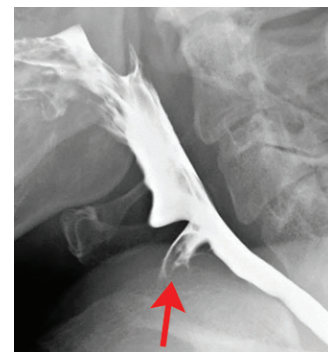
Frozen pharynx in a 68-year-old woman with a history of radiation therapy. Lateral radiograph shows absent contractions and rigidity of the pharyngeal walls during the passage of bolus and penetration of contrast material into the larynx (arrow).
